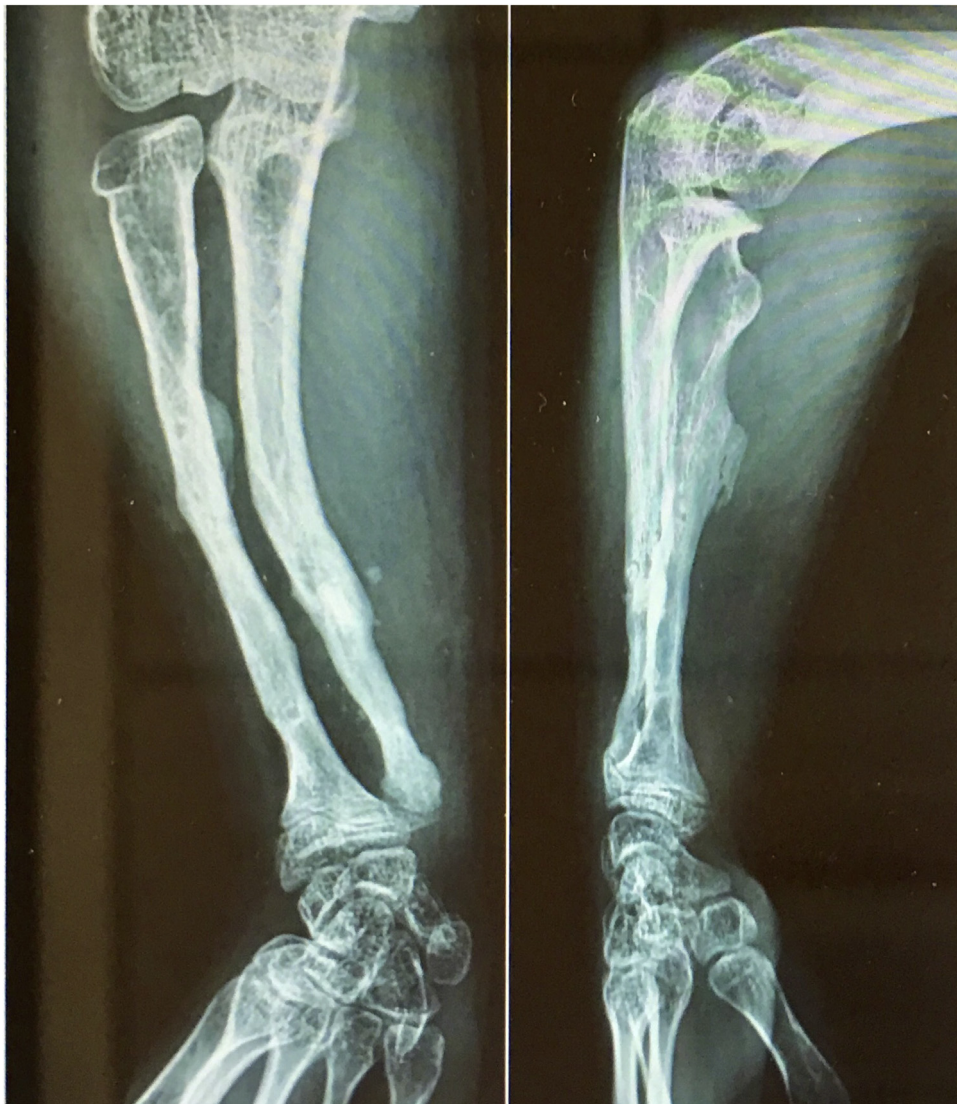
X-Ray after removing the plate and the plate and the K-wire.
